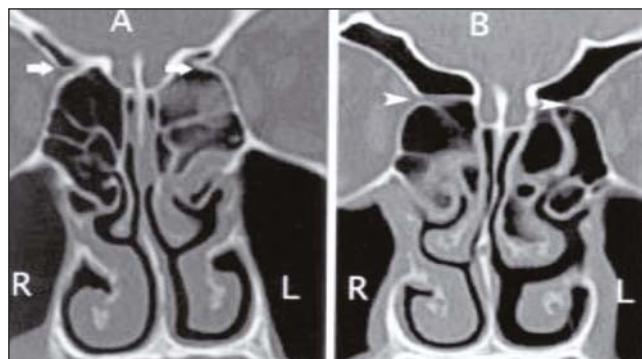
Coronal sinus CT scan showing course of anterior ethmoid artery
